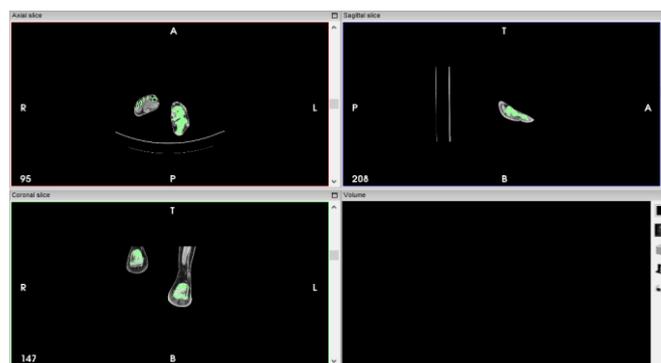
CT-photos by InVesaliusban
